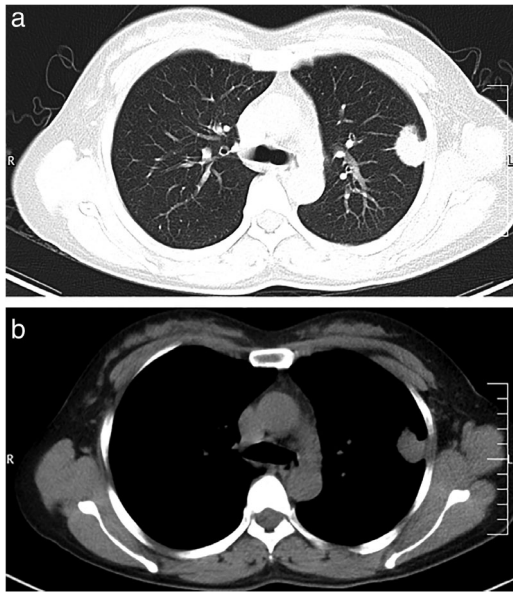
Chest CT images when the tumor was first discovered. (a) Pulmonary window. (b) Mediastinal window
